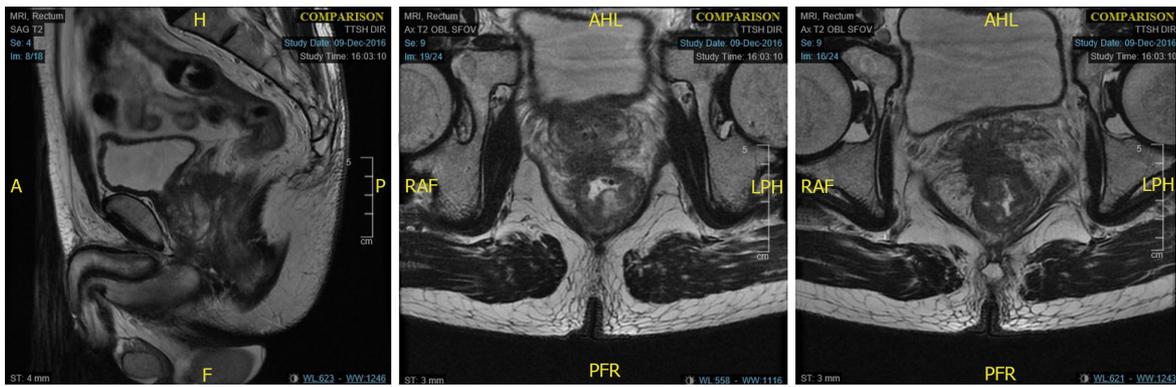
Magnetic resonance imaging demonstrating T4 low rectal tumour with prostate and bilateral seminal vesicle invasion.
